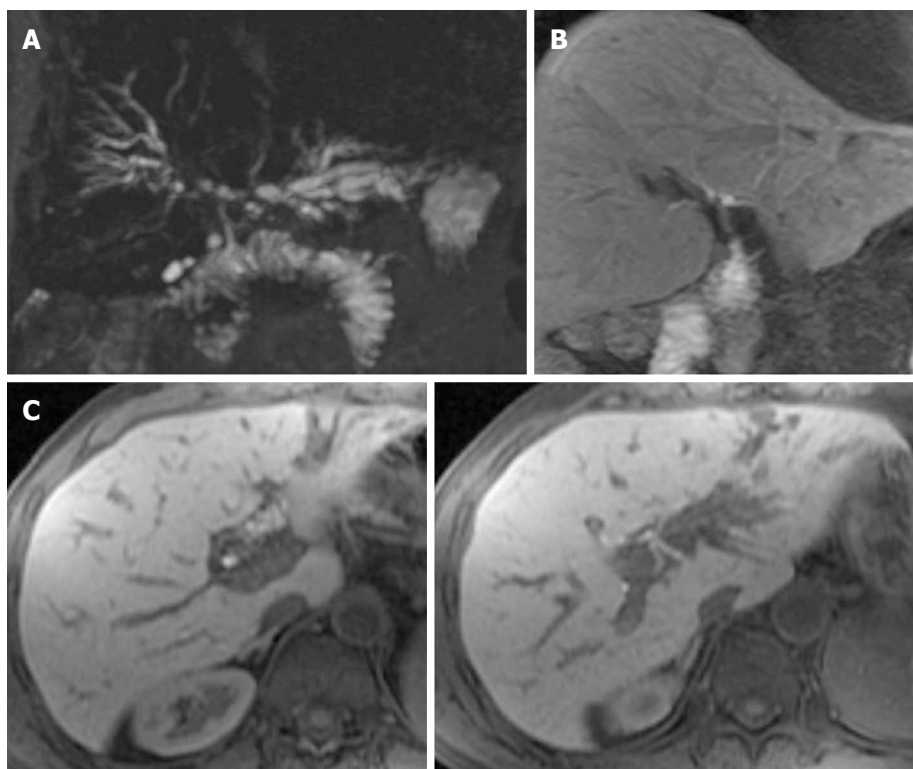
Recurrence of primary sclerosing cholangitis in a transplant patient with hepatico-jejunostomy. A: Maximum intensity projection (MIP) reconstruction of 3D thin-slab fast spin-echo T2-weighted images shows multifocal stenosis with intervening saccular dilation affecting the intrahepatic biliary system; B, C: On MIP reconstruction and axial Gd-EOB-DTPA enhanced LAVA T1-weighted sequences the intrahepatic biliary system is not appreciable, however the irregularities of the extrahepatic biliary tract are more accurately depicted.
